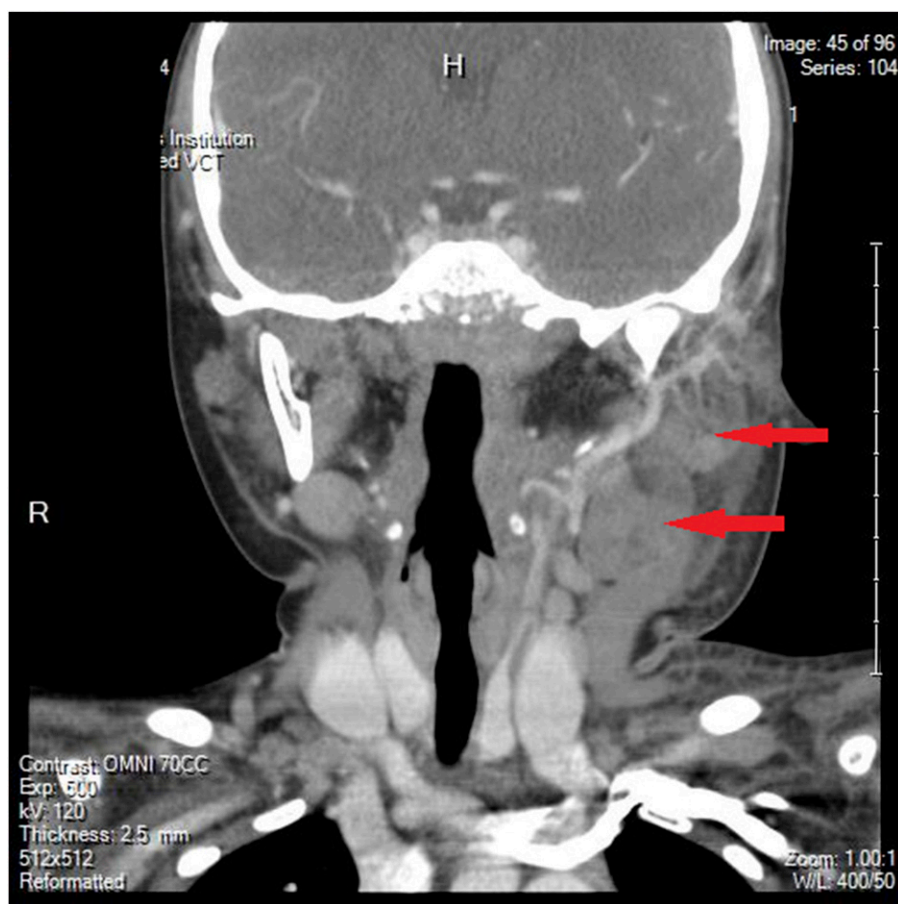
Lymphadenitis shown on a computed tomographic scan of the head and neck.
